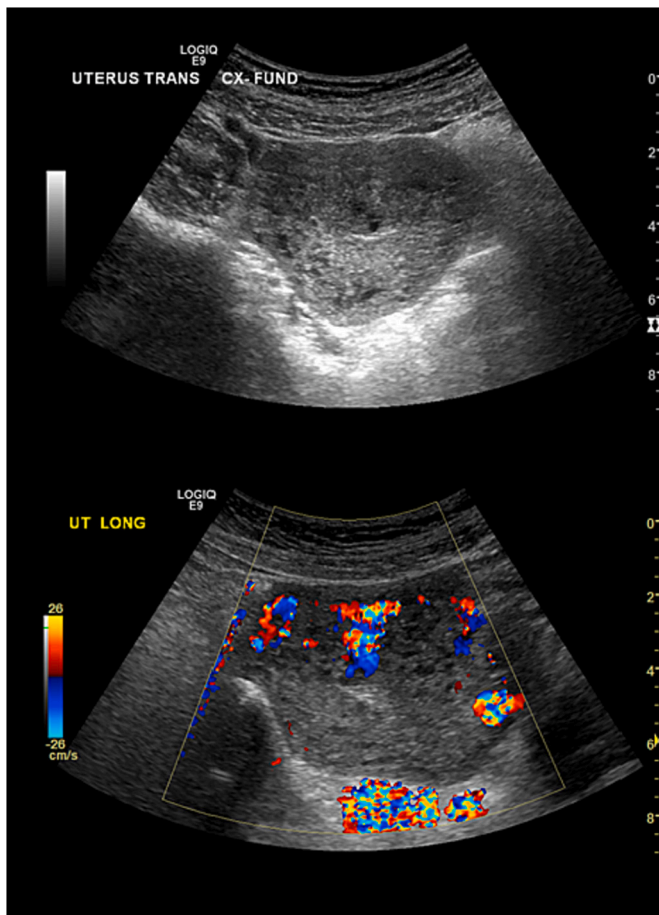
Tertiary-level ultrasound performed 3 weeks post-dilation and curettage. Images of the fundal myometrium show highly vascular areas and overlapping arterial and venous waveforms consistent with a diagnosis of atypical AVM.
